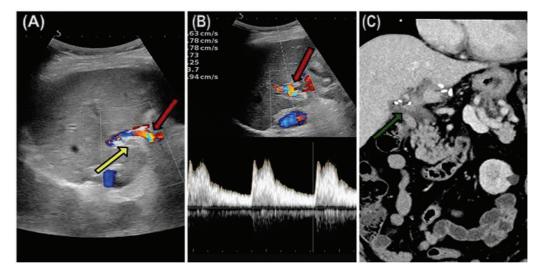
A 63-year-old male patient with orthotopic liver transplant after 5 months. Ultrasound (USG) images of the porta hepatis shows absent color uptake in the main portal vein (A, yellow arrow) with hypertrophied and tortuous hepatic artery (B, red arrow)—consistent with thrombosis in main portal vein and compensatory increase in hepatic artery flow. Contrast-enhanced computed tomography (CECT) coronal image (C) of the upper abdomen shows nonopacification of main portal vein (green arrow), s/o thrombosis of main portal vein.
